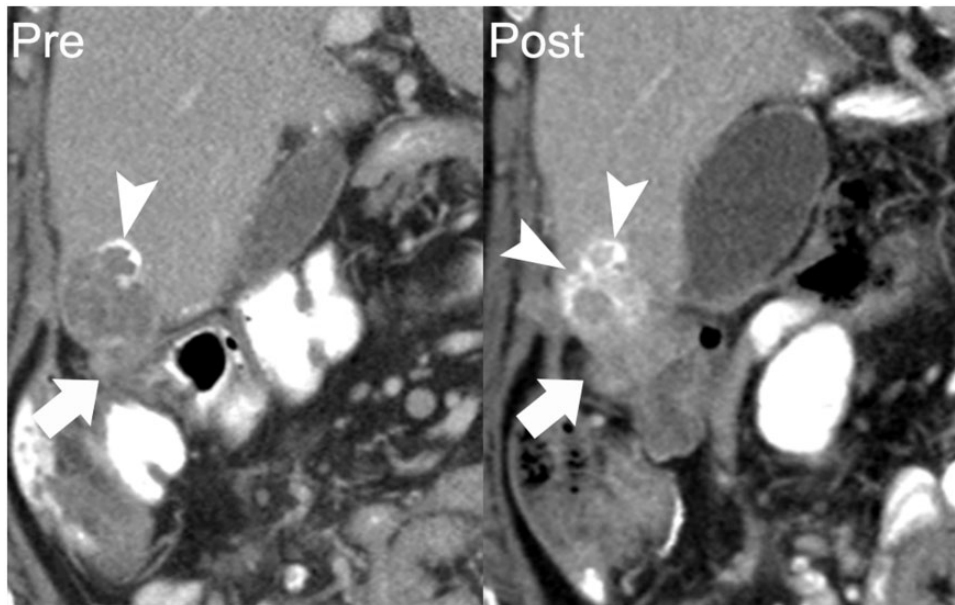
A 62-year-old woman with papillary serous ovarian adenocarcinoma with calcified peritoneal metastases. Coronal reformatted image from a contrast-enhanced CT shows a perihepatic implant with peripheral calcification (arrow on left). Follow-up CT 11 months later shows the inferomedial component of this lesion to be enlarging (arrow on right). Increasing density of calcification occurred in the setting of disease progression (arrowheads). Over this period, her cancer antigen 125 (CA125) level increased from 57 to 162 units/ml.
